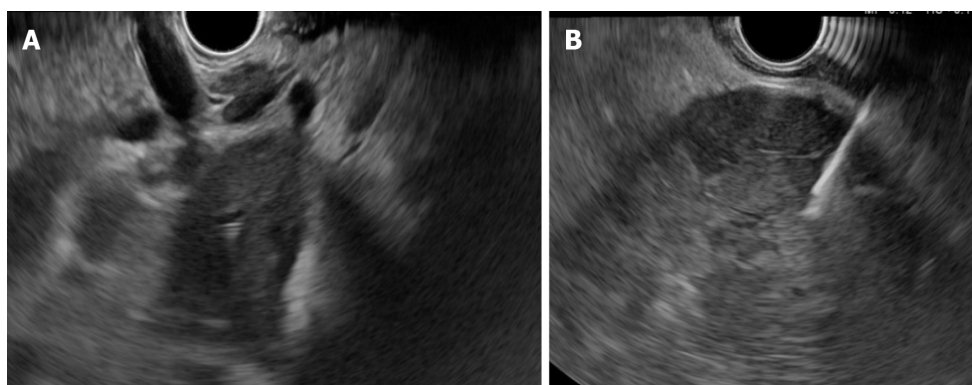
Endoscopic ultrasound for liver evaluation. A: Hilum view of the liver tumoral mass; B: Fine needle aspiration guided endoscopic ultrasound for left lobe intrahepatic cholangiocarcinoma.
